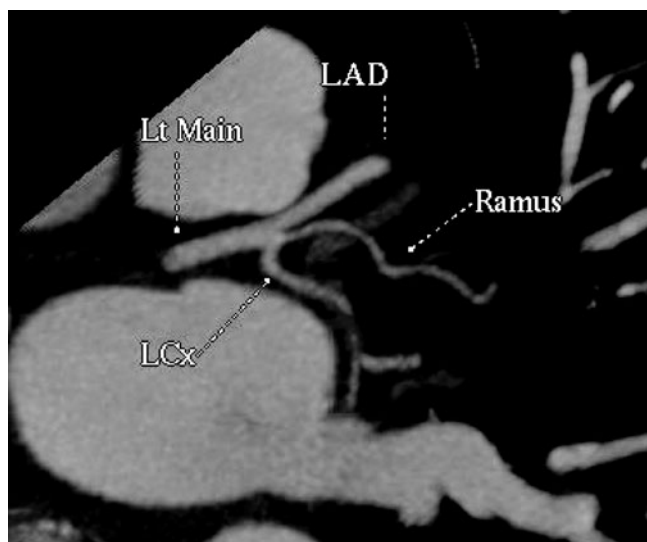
Selected coronary computed tomography angiography (CTA) image of the proximal left coronary arterial system in a patient scheduled for isolated mitral valve surgery. Using the protocol detailed in this chapter, CT demonstrated normal coronary arteries in this patient, eliminating the need for arterial catheterization.
